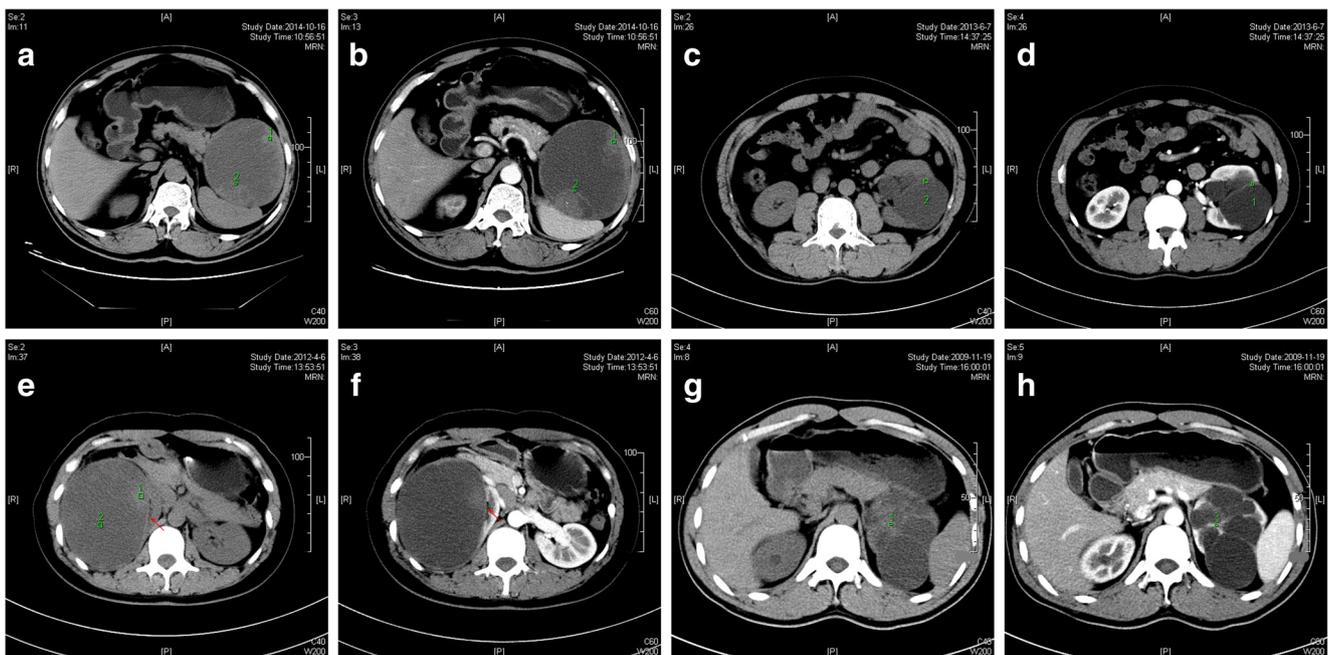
a and b A Bosniak IIF mass. a The pre-contrast phase. b The corticomedullary phase. The septa and wall of this mass were thickened, but there was no measurable enhancement. The CT value of Box 1 in (a) is 33.7; the CT value of Box 2 in (a) is 29.4; the CT value of Box 1 in (b) is 48.2; the CT value of Box 2 in (b) is 41.2. The wall point of this mass is 2, the septum point is 2, the nodule point is 2, and the content point is 1; thus, the RCI of this mass is 12.299, which indicates a higher risk of malignancy. This mass was proven to be a papillary renal cell carcinoma. c and d A Bosniak III mass. c The pre-contrast phase. d The corticomedullary phase. The septa of this mass are thickened, which measurable enhancement. The CT value of Box 2 in (c) is 15.6; the CT value of Box 1 in (d) is 39.6. The wall point of this mass is 1, the septum point is 3, the nodule point is 1, and the content point is 1; thus, the RCI of this mass is 6.325, which indicates a lower risk of malignancy. This mass was proven to be a benign complex renal cyst. e and f A Bosniak IIF
